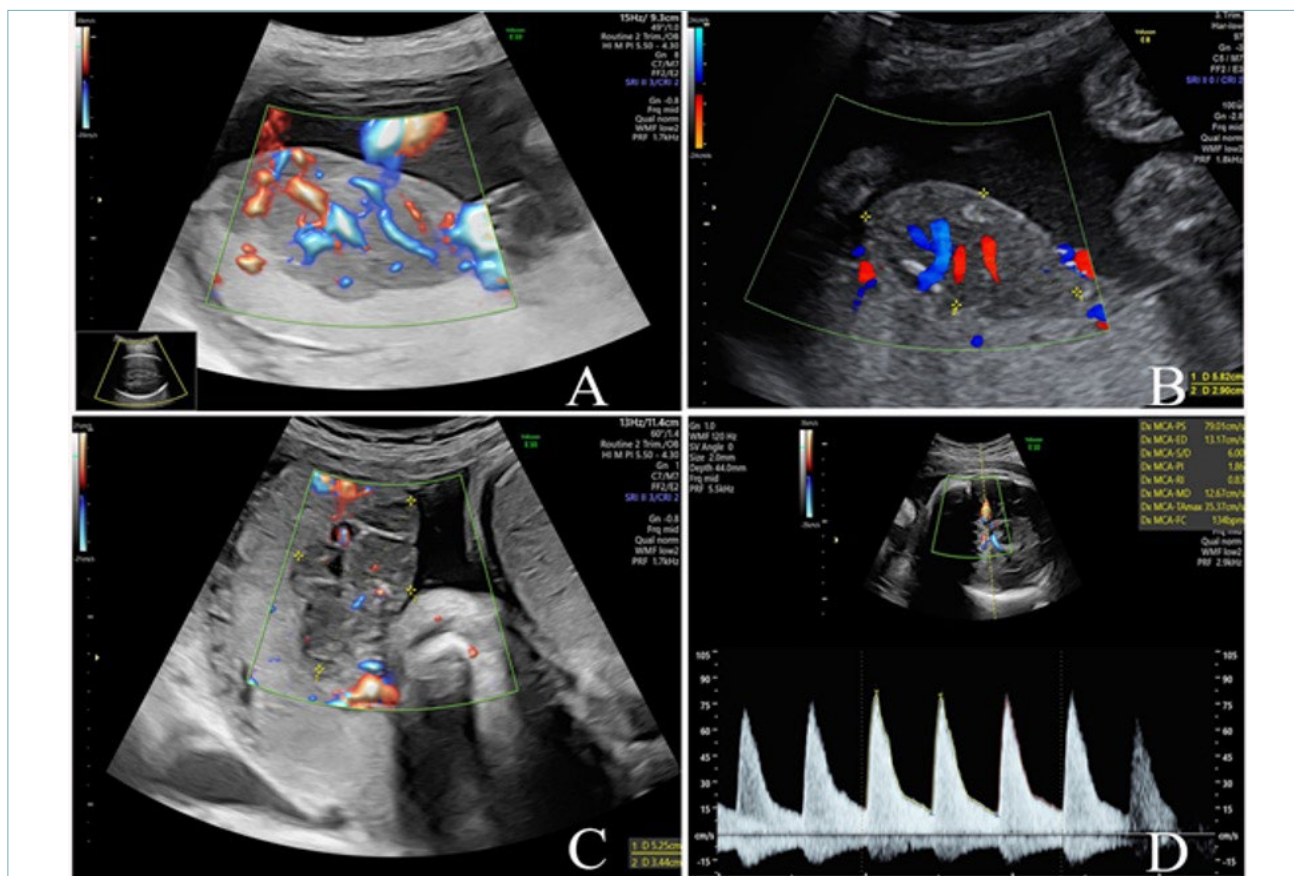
Sonographic features of a large chorioangioma. (A) 25+3 weeks: color Doppler flow imaging demonstrates large vascular channels within the tumor; (B) Size of the mass at 27+ 6 weeks; (C) Size of the mass at 34+5 weeks. (D) Pulsed-wave Doppler of the middle cerebral artery demonstrating increased peak systolic velocity.
